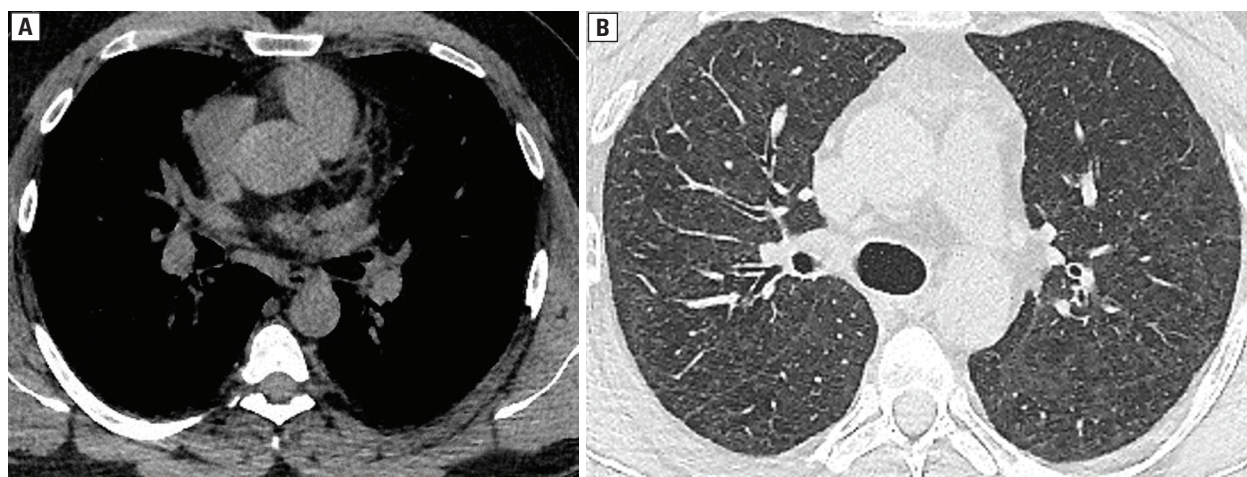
Contrast non-enhanced CT scan, mediastinal window, depicts regression of mediastinal and hilar adenopathy; B. HRCT scan shows partial regression of nodules
